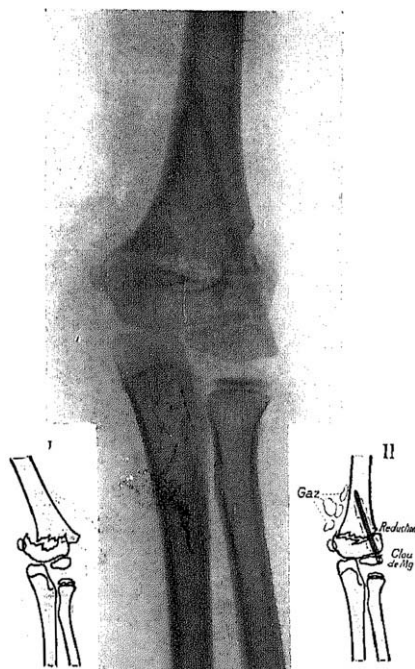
Verbrugge demonstrated a postoperative X-ray of a supracondylar fracture of a 7 year old child treated with a Dow magnesium nail [9]. The early onset of subcutaneous gas formation can be seen [9].
